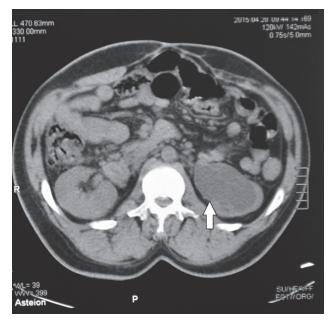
CT abdomen. Hydroureteronephrosis of the left kidney due to pelviureteric junction obstruction (arrow).
